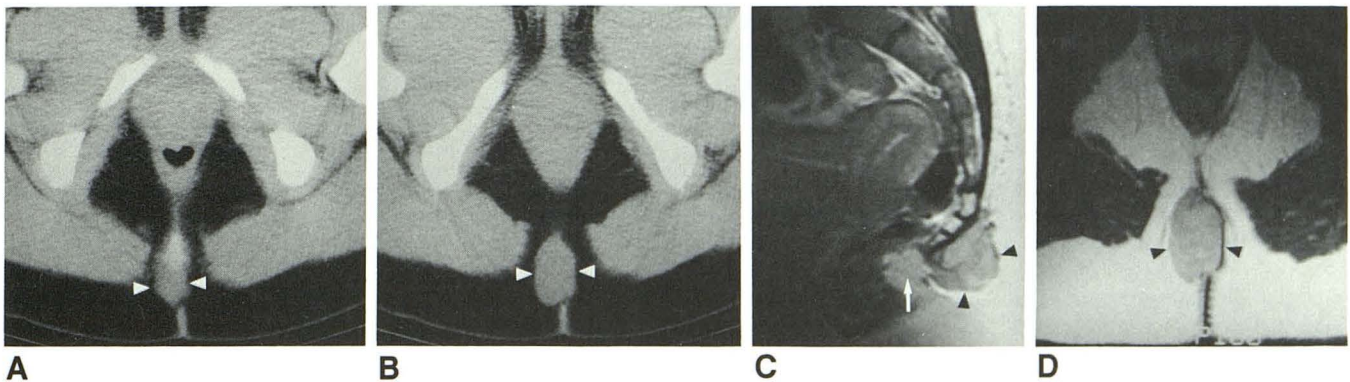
Subcutaneous sacrococcygeal myxopapillary ependymoma. A and B, Axial CT scans at level of coccyx (A) and 3 cm below it (B) show a midline lesion 3 × 4 cm (arrowheads) immediately deep to natal cleft. Lesion is in contact with dorsal surface of coccyx without evidence of bone erosion. C and D, Contrast-enhanced sagittal (C) and axial (D) T1-weighted, 700/20/2, MR images show a sharply defined mass in contact with dorsal surface of distal coccyx. Heterogeneous, enhancing mass (arrowheads) is hyperintense relative to muscle. Tissue immediately in front of tumor (arrow) is normal fat. High signal in marrow space of distal coccygeal segments is due to fatty tissue and not enhancement.
